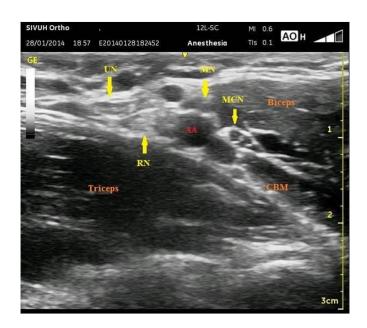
Ultrasound scout scan of axilla showing AV: axillary vein(s). UN: ulnar nerve, MN: median nerve, RN: radial nerve, AA: axillary artery
